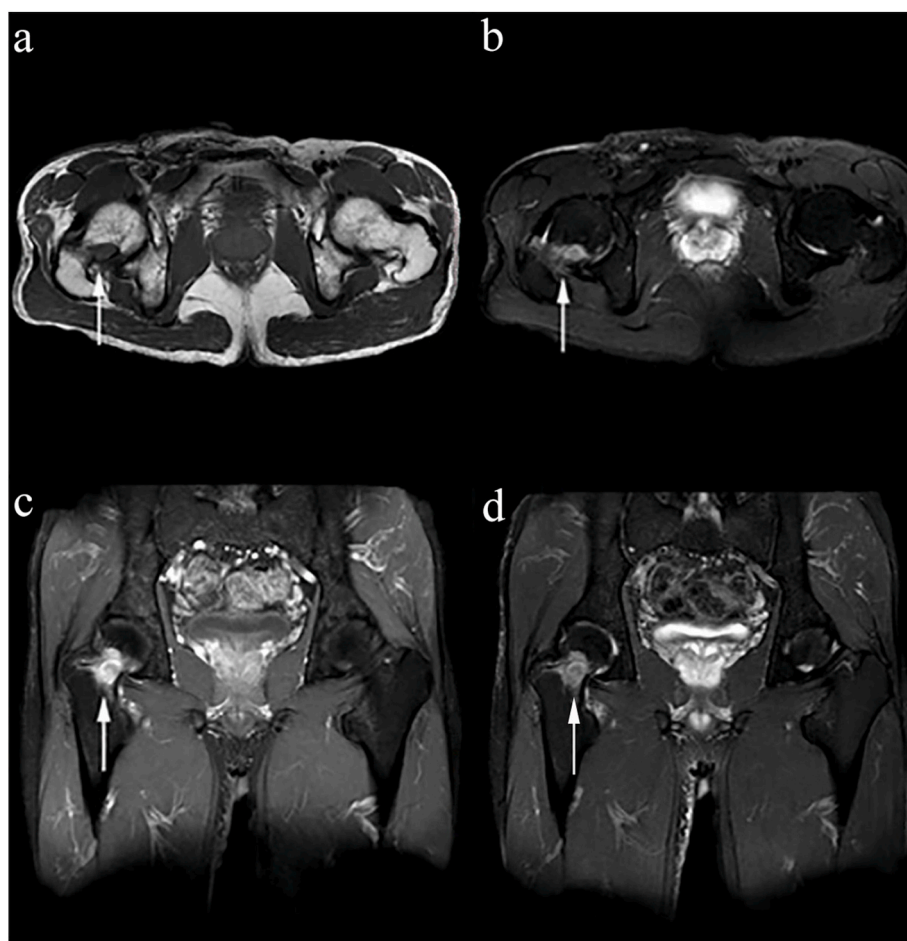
The presence of the femoral neck bone destruction in the MRI after partial penectomy with right inguinal lymphadenectomy. (a) The lesion of femoral neck (white arrow) was low signal in T1-weighted MRI. (b) The lesion (white arrow) has slightly high signal T2-weighted MRI. (c,d) The metastatic lesion (white arrow) was located in femoral neck and showed significant enhancement both in coronal T1-weighted imaging(c) and coronal T2-weighted imaging(d).
